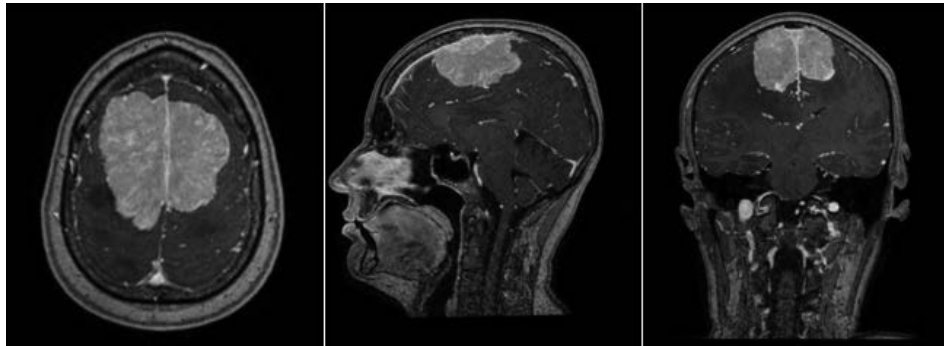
MRI scan in transverse (left), sagittal (middle) and frontal (right) projection
